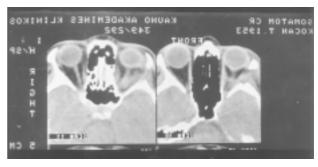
CT scans 1 week after operation demonstrate slight swelling of lateral and medial rectus muscles and removed lateral wall of the left orbit (Pre- and postoperative scans are made by different CT scanners. For better comparison we put postoperative scan in inverse position)
